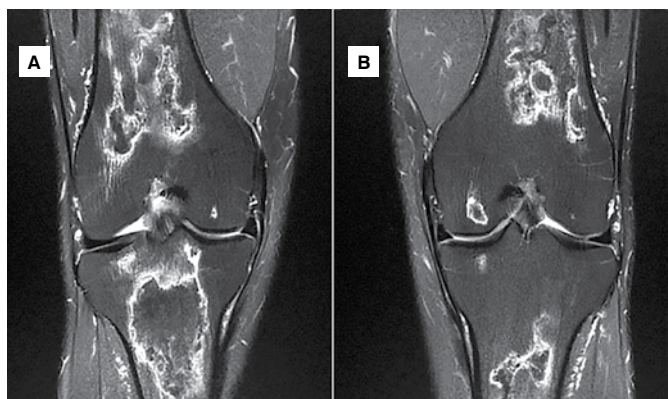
MRI of the knees showing bilateral involvement without joint collapse: (A) right, (B) left.
